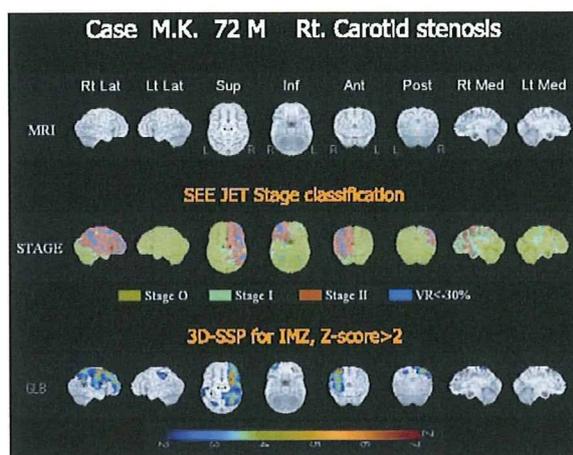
血行力学的脳虚血に伴う不完全脳梗塞のSPECT画像解析
